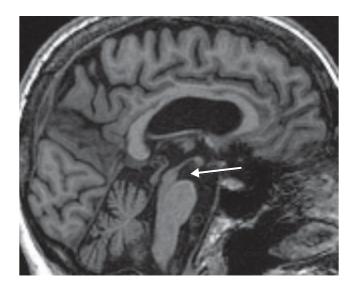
Magnetic Resonance Imaging of Progressive Supranuclear Palsy.
